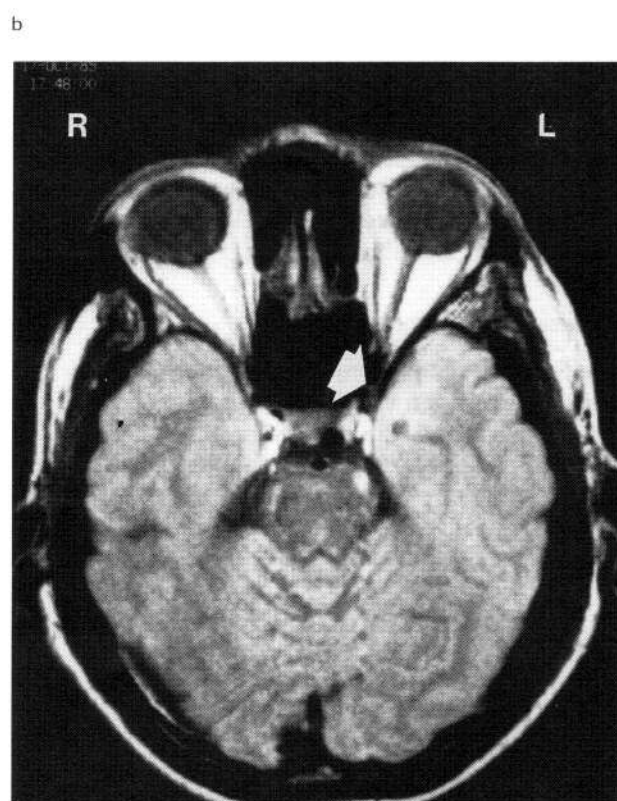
a) A 46-year-old female patient with complex partial epilepsy had an EEG focus in the left temporal lobe. Hypoperfusion observed in the HM-PAO scan also was located in the left temporal lobe. b) Although CT of the head was repeatedly normal, MRI revealed a small lesion in the same area.
